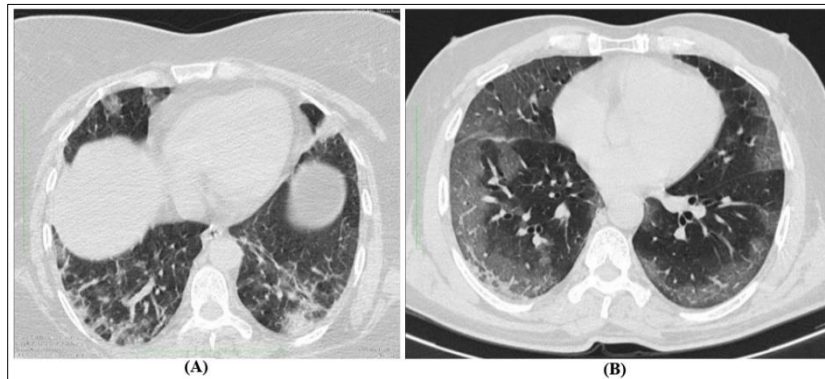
Image (A) Non contrast chest CT of 54-year-old RT-PCR positive female patient. Axial section showing sub-pleural fibrotic bands and dilated vascular markings along with sub segmental atelectasis and areas of GGOs. Image (B) Non contrast chest CT of 64-year-old RT-PCR positive male patient. Axial section shows multifocal non-segmental ground glass opacities and subpleural consolidation noted in the right lower lobe with bronchiectasis.
